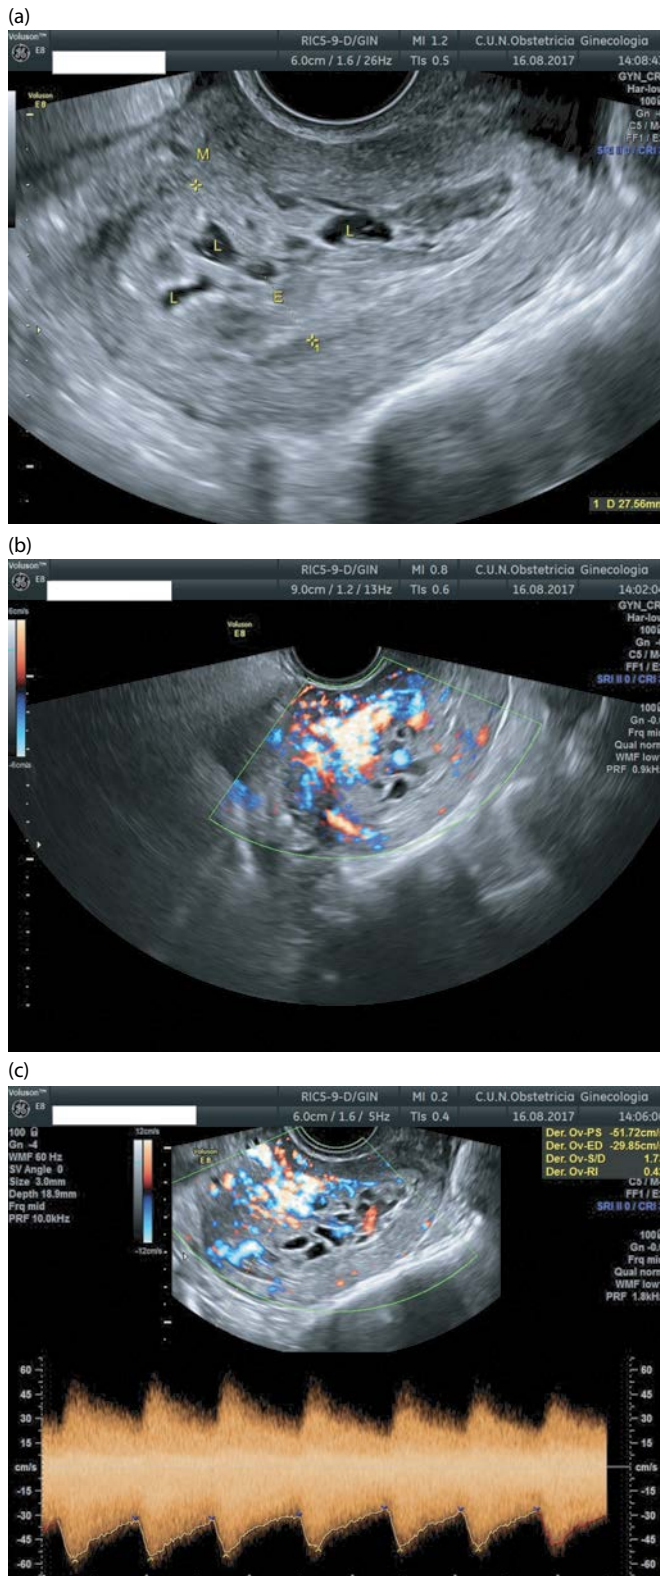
Transvaginal ultrasound showing a case of arteriovenous malformation after spontaneous first-trimester miscarriage. Large cystic areas (L) can be observed (a). With color Doppler, we can observe how most of these cystic areas are actually blood vessels (b) that exhibit high-velocity and low-resistance blood flow (c).
